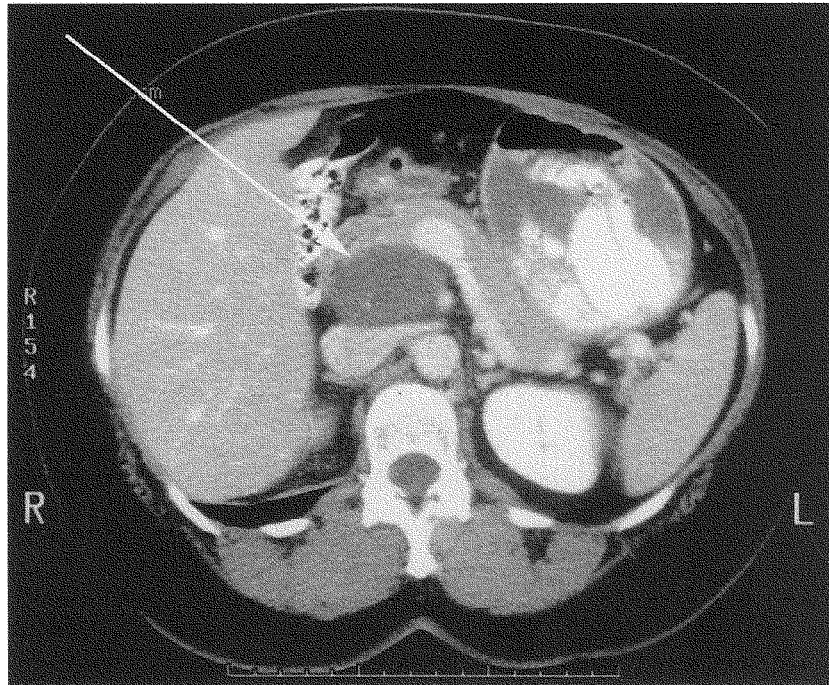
CT scan showing a 3.5 × 5.0 cm unilocular cystic mass just dorsal to and probably involving the head of the pancreas and uncinate process (arrow), stippled with central calcifications. Only one calcification can be seen on this image; however, the relationship of the mass to surrounding structures is well depicted. The mass partially compresses the underlying inferior vena cava, displaces the portal vein to the left at the splenic vein junction, and displaces the superior mesenteric artery to the left.
